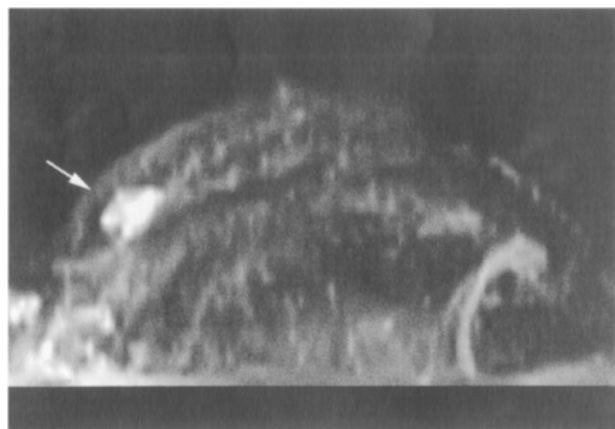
Magnetic resonance imaging (MRI) was performed on a Siemens 1.5-T MR imager with a 3D fast low-angle shot (FLASH) sequence. MRI showed an irregular mass with early enhancement 1 minute after IV injection of gadolinium diethylenetriamine-pentaacetic acid (Gd-DTPA) (arrow), and no washout for 6 minutes.
